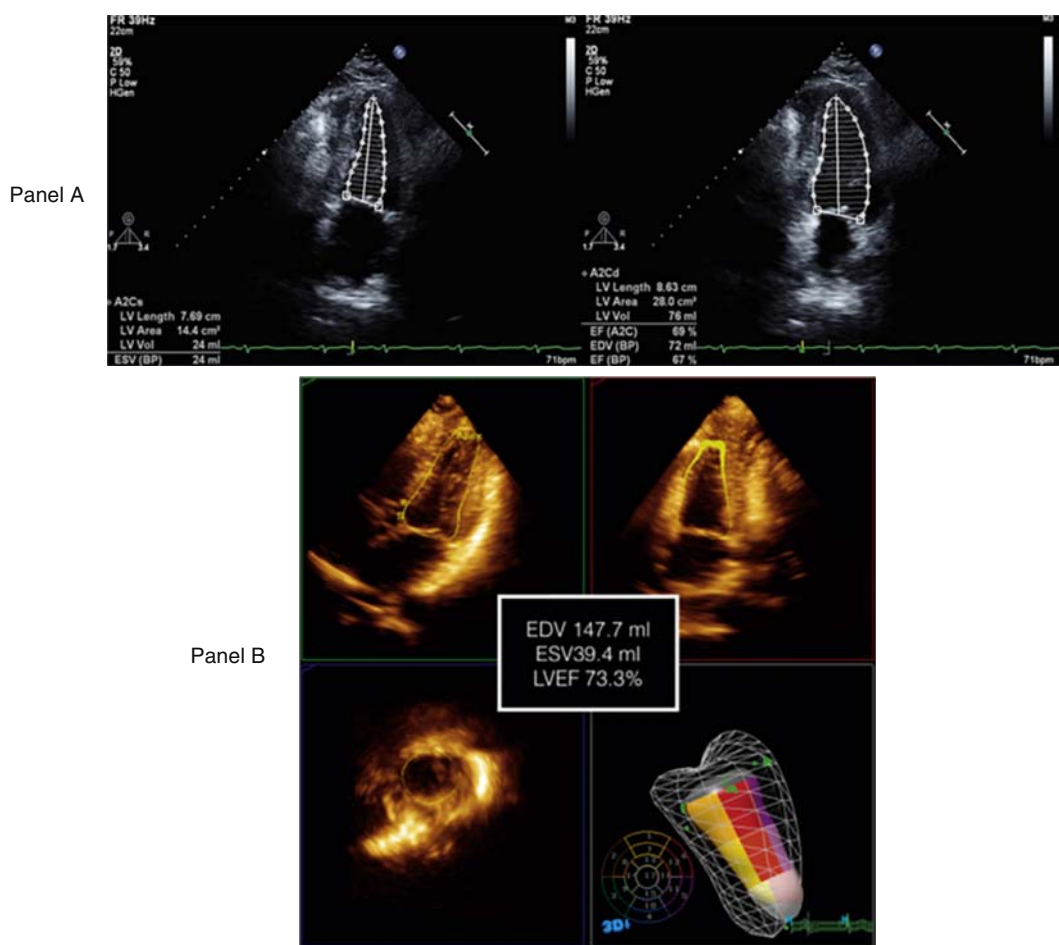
Example of 2D and 3D Echocardiography With Measurement of the LVEF by the Modified Simpsons Biplanar Quantification Method With the Left Ventricular Endocardial Border Traced in End-Systole and End-Diastole to Create Disks Forming a Cylinder (Panel A) and 3D Dimensional Assessment. LV, left ventricular; LVEF, left ventricular ejection fraction. (Reproduced from Garg V, Vorobiof G. Echocardiography and alternative cardiac imaging strategies for long-term cardiotoxicity surveillance of cancer survivors treated with chemotherapy and/or radiation exposure. *Curr Oncol Rep.* 2016;18:52 with permission.)
